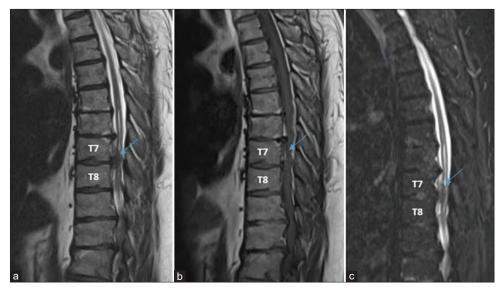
Magnetic resonance imaging of the thoracic spine with T2-weighted sagittal image (a). It is showing an anterior dural/epidural rounded nodule of 3-4 mm (blue arrow) of low signal intensity at the disc level between vertebra 8 and 9 with features of secondary compressive myelopathy. It includes attenuated caliber, central hyperintensity, and syringohydromyelia. It is isointense in T1 weighted (b) and hypointense in short-tau inversion recovery sequence (c).
